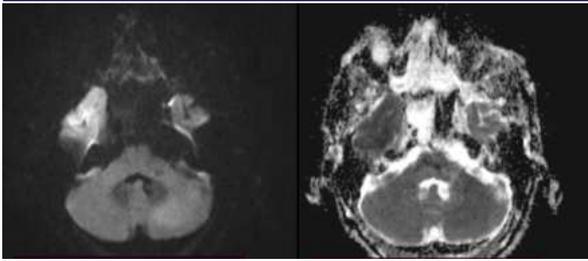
DWI shows hyperintense lesions in left cerebellar hemisphere with low ADC values representing
